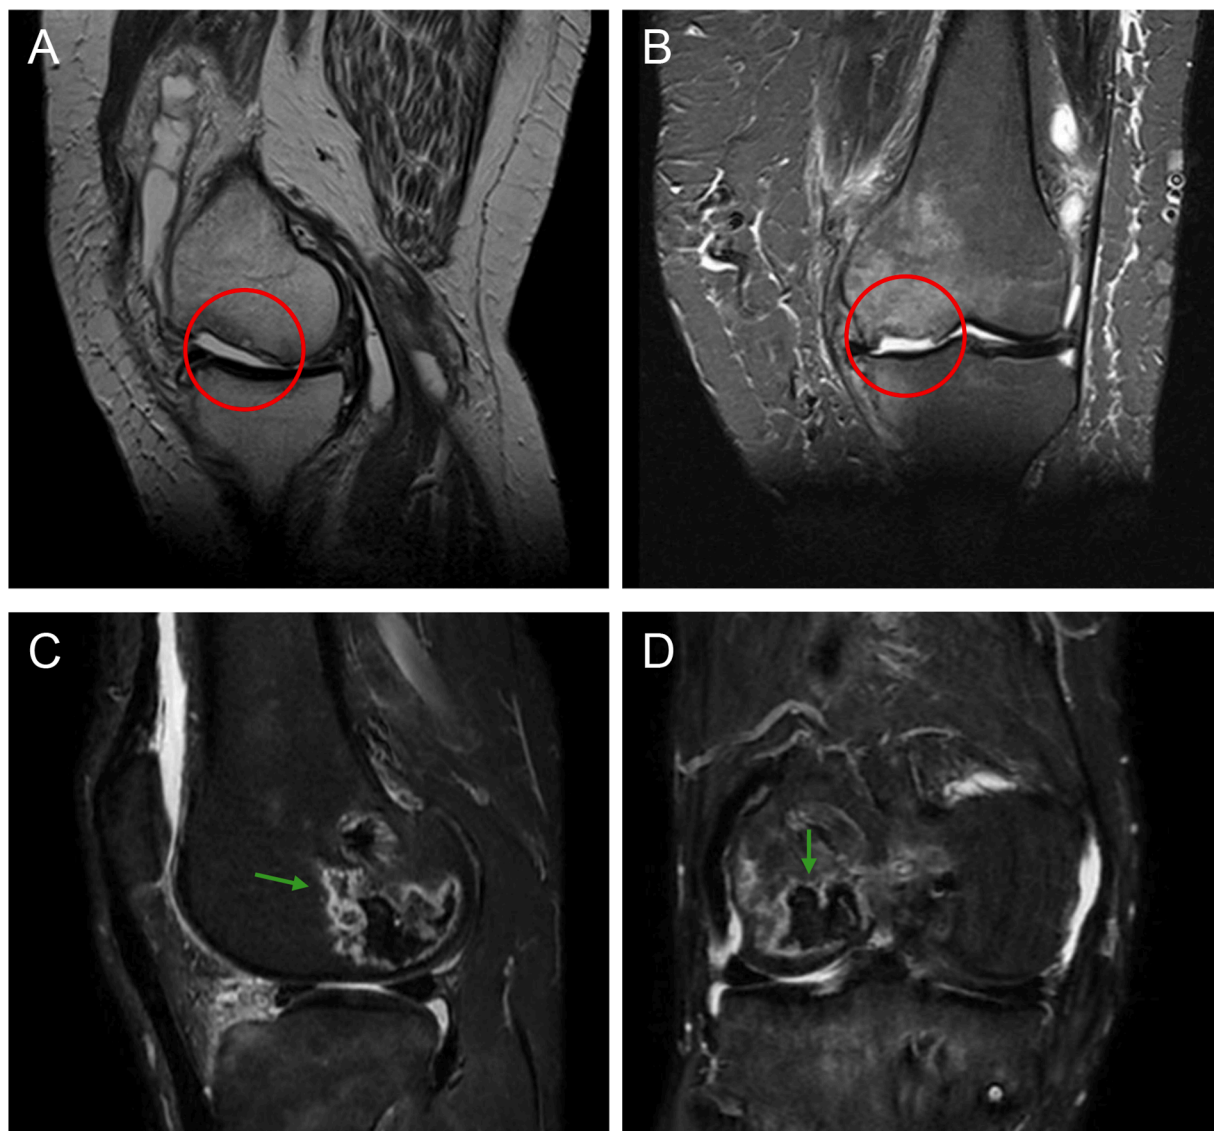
Abbreviations: CCS = corticosteroid; MFC = medial femoral condyle; MRI = magnetic resonance imaging; ON = osteonecrosis; PONK = post-arthroscopic osteonecrosis of the knee; SONK = spontaneous osteonecrosis of the knee.
